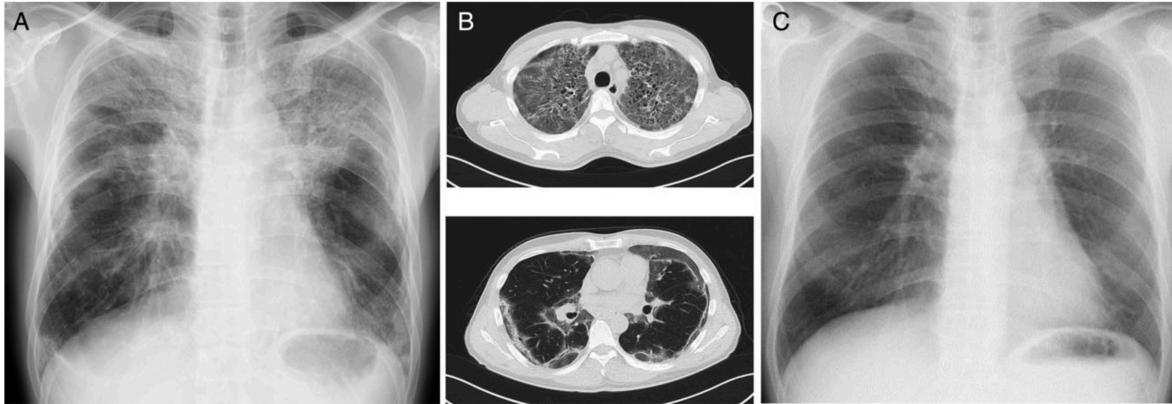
Chest radiography of EVALI patient
